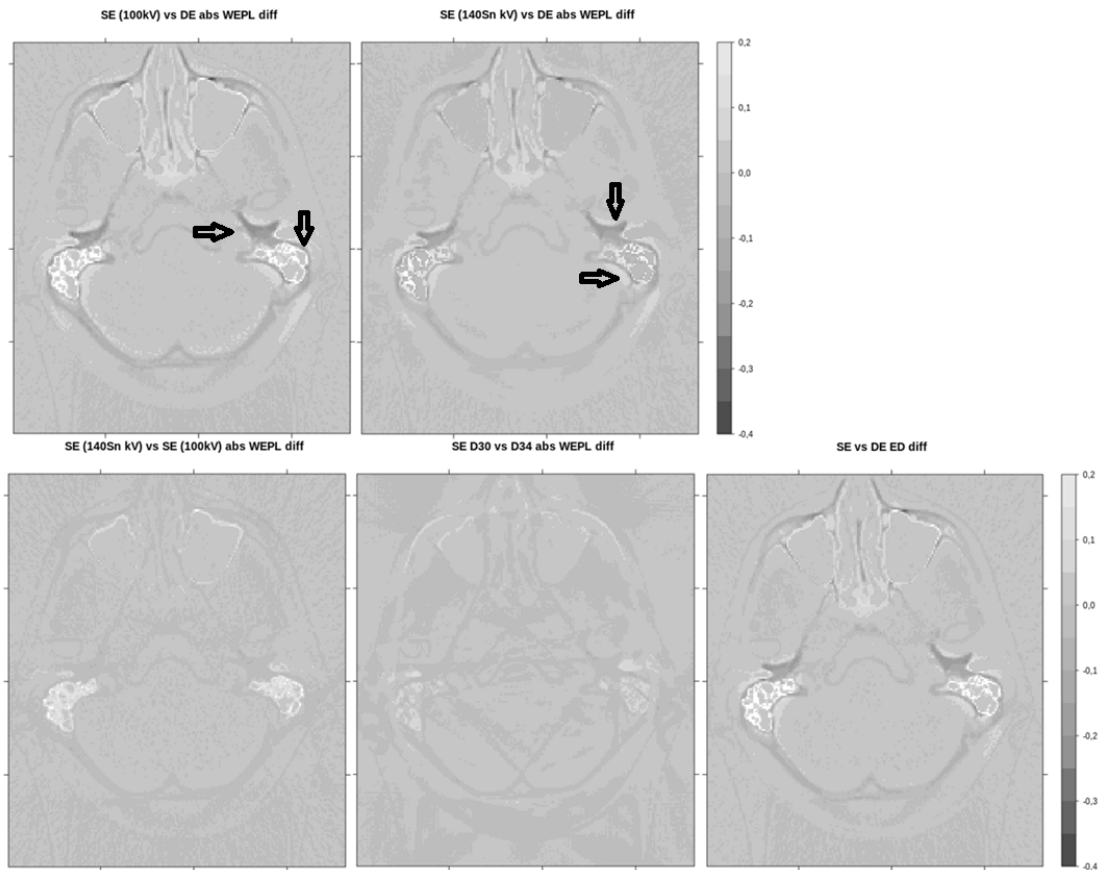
Absolute differences of WEPL predicted from SECT ("SE") and DECT ("DE") for different voltages and kernels. A systematic WEPL difference can be observed for the dense temporal bone and mastoid cavity. This difference in WEPL is directly related to the difference in $\hat{\rho}_e$ prediction from SECT and DECT (last panel). The SECT-based $\hat{\rho}_e$ prediction at 100 kV was derived with a stoichiometric calibration that converts CT numbers to $\hat{\rho}_e$ usually employed in photon therapy.
